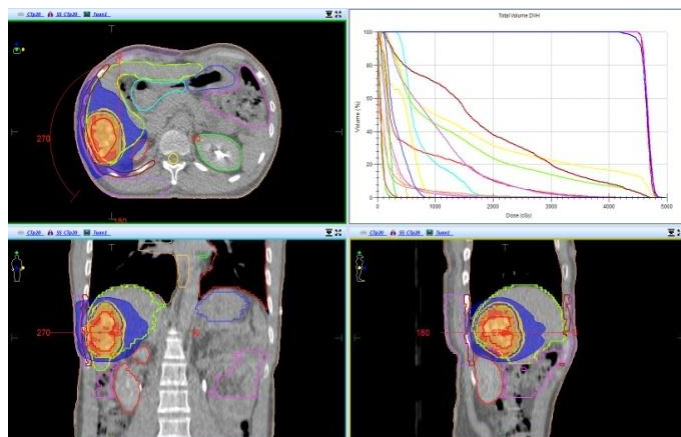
Isodose curve shown on CT images (liver).
